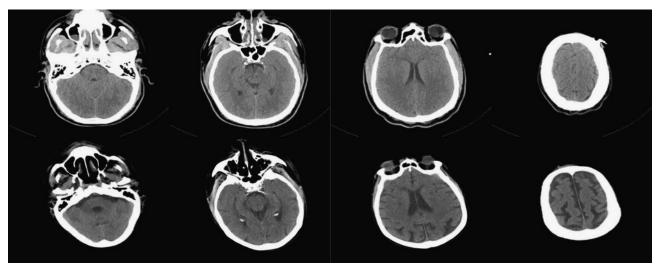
Normal head CT of 28 year old (top row) and an 88 year old (bottom row) demonstrating age-related changes and atrophy.
